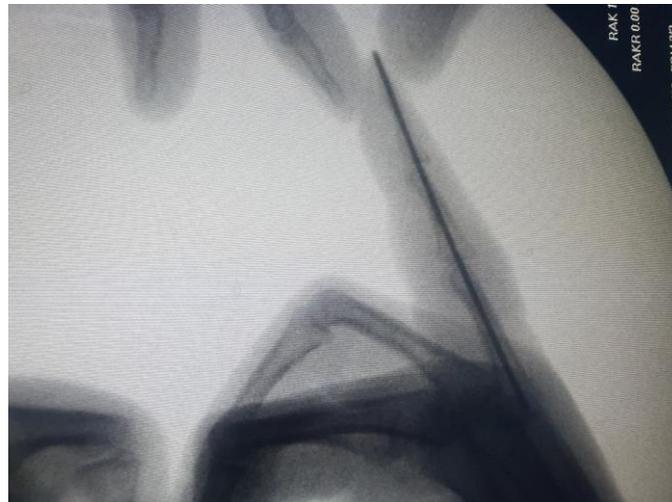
Profile X-Ray of the pin
